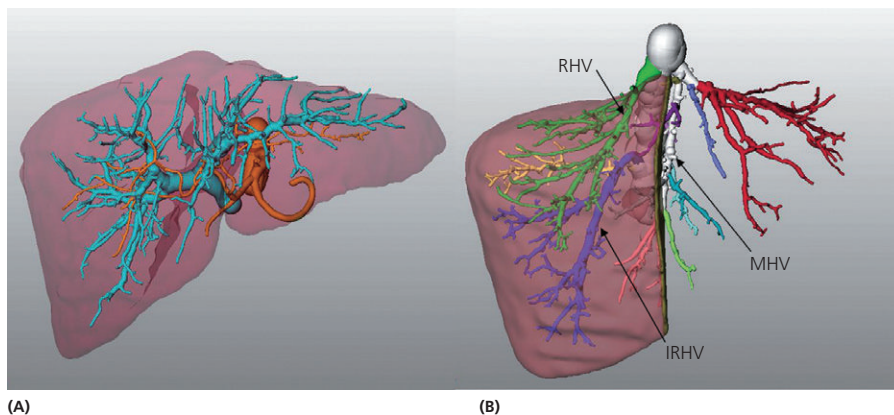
Three-dimensional reconstruction of the (A) hepatic artery and portal vein and (B) estimated right lobe graft without middle hepatic vein using multiphase CT scan. RHV, right hepatic vein; MHV, middle hepatic vein; IRHV, inferior right hepatic vein.
